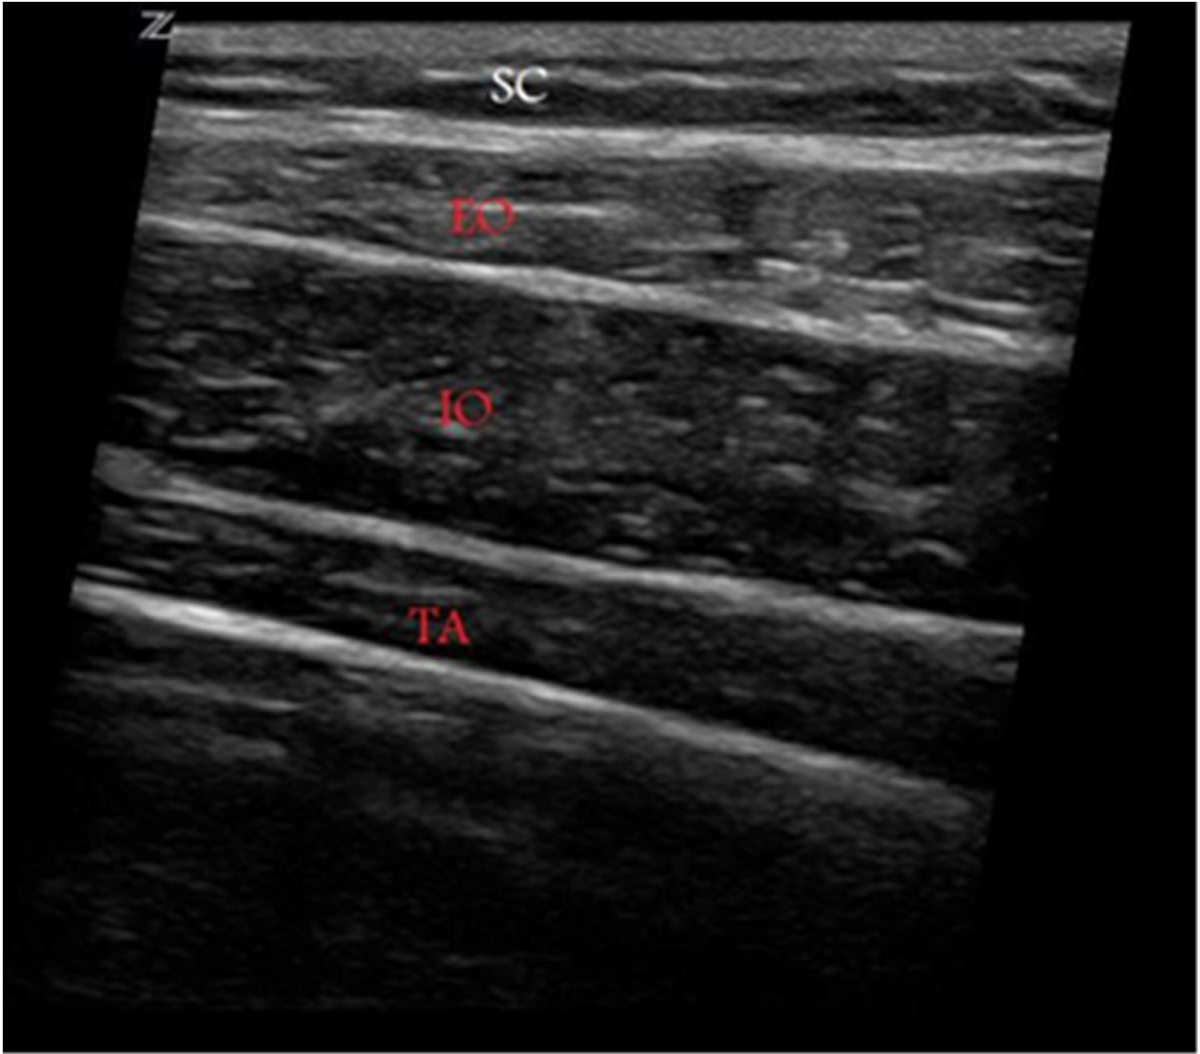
SUBCOSTAL TECHNIQUE(ULTRASOUND IMAGE)
